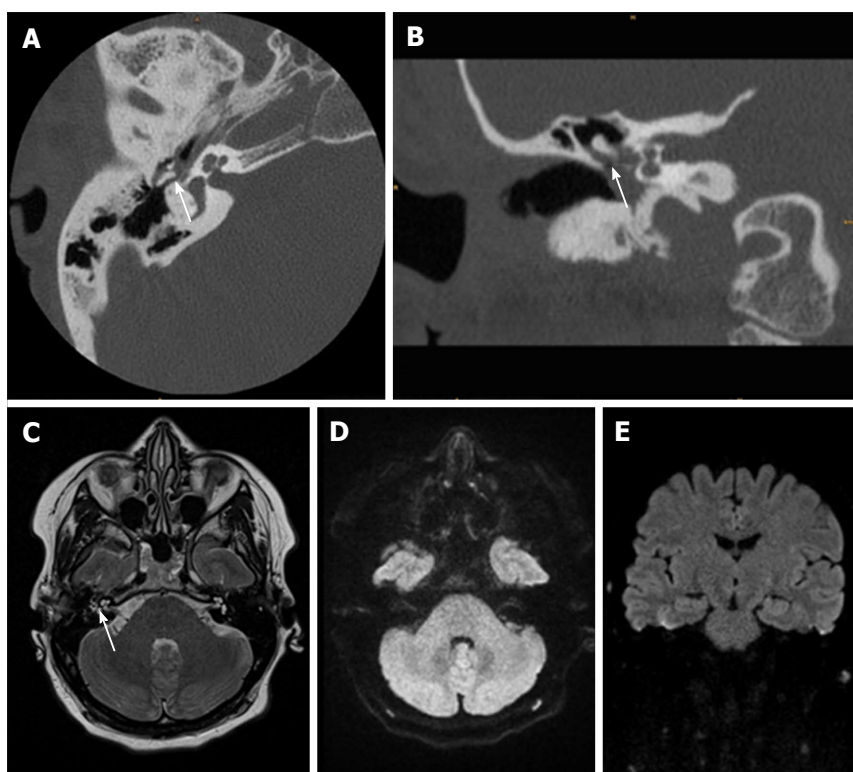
Thirty-one-year-old female after surgery for cholesteatoma. A, B: CT show a soft-tissue mass in the tympanic space adjacent to malleolus and scutum with suspected bony erosion (white arrow); C-E: Axial T2 weighted image shows fluid-like signal (white arrow) that has no restriction in EPI DWI RESOLVE (axial in D and coronal in E). There was no sign of recurrent cholesteatoma on follow-up surgery. CT: Computed tomography; DWI: Diffusion weighted imaging; EPI: Echo-planar imaging; RESOLVE: Readout-segmented echo-planar.
